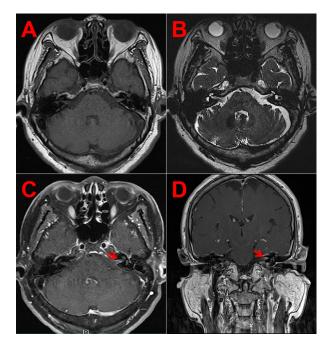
MRI results of patient 3. MRI showed T1-MPRAGE and high T2 (3D-CISS) signals in the brainstem (A,B). Head MRI enhancement showed that the central canal's facial nerve and vestibular nerve had an enhanced signal (C,D, red arrow).
